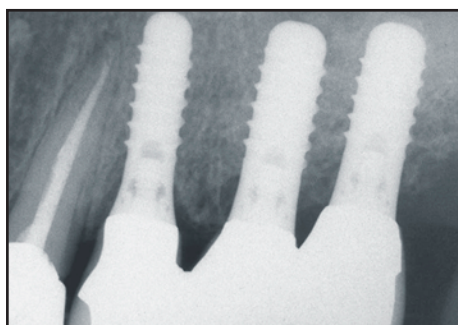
Periapical radiograph of implant-supported prosthesis that was taken 15 months after placement.
